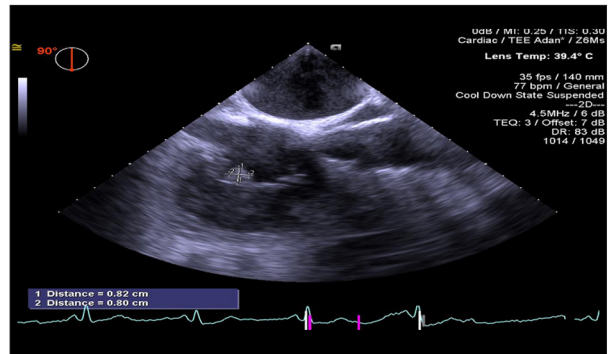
Preoperative transesophageal echocardiogram (TEE) of a 43-year-old man with a history of systemic lupus erythematosus (SLE) who presented with endocarditis associated with Q fever due to infection with *Coxiella burnetii*. The image, which shows a mass on the repaired tricuspid valve, was taken in 2018.
